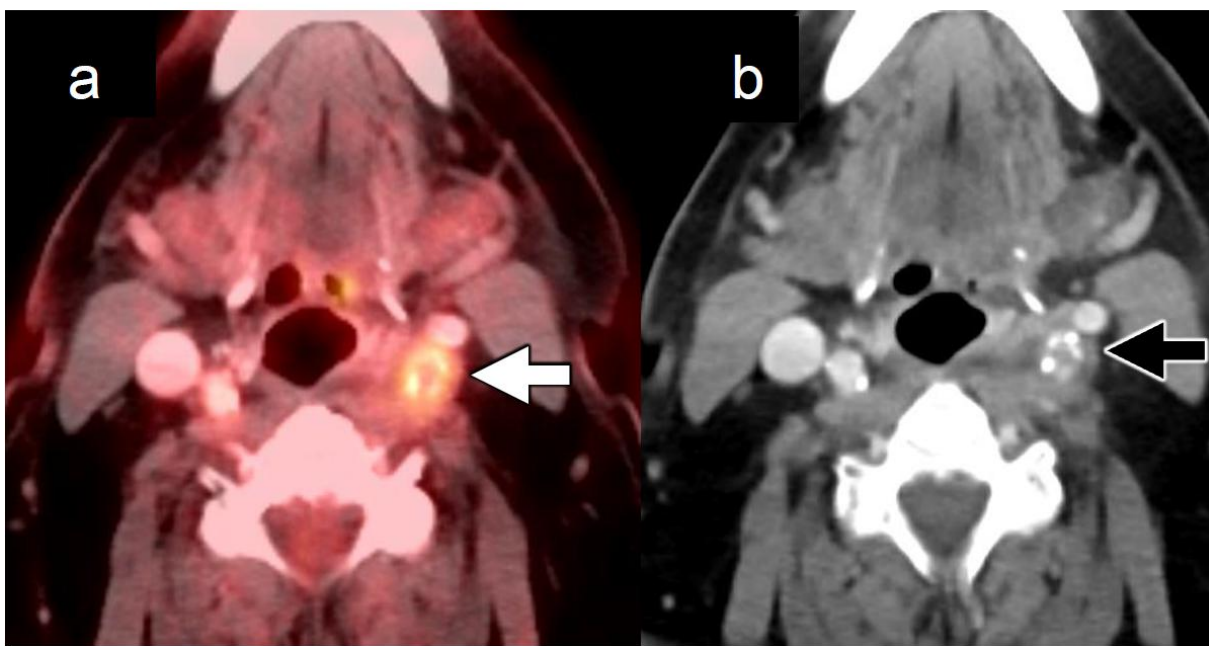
FDG uptake due to atherosclerosis. Fused axial FDG-PET/CT (a) in a patient with esophageal adenocarcinoma shows an isolated focus of hypermetabolic activity within the left suprahyoid neck (white arrow). A metastatic level II lymph node would be an unusual location for an isolated metastasis from esophageal carcinoma.
